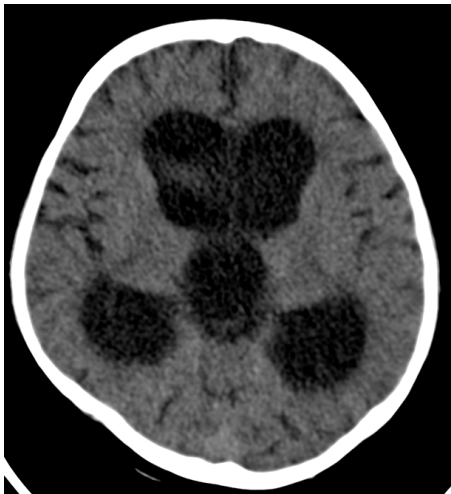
CT brain showing hydrocephalus with enlarged ventricles.
